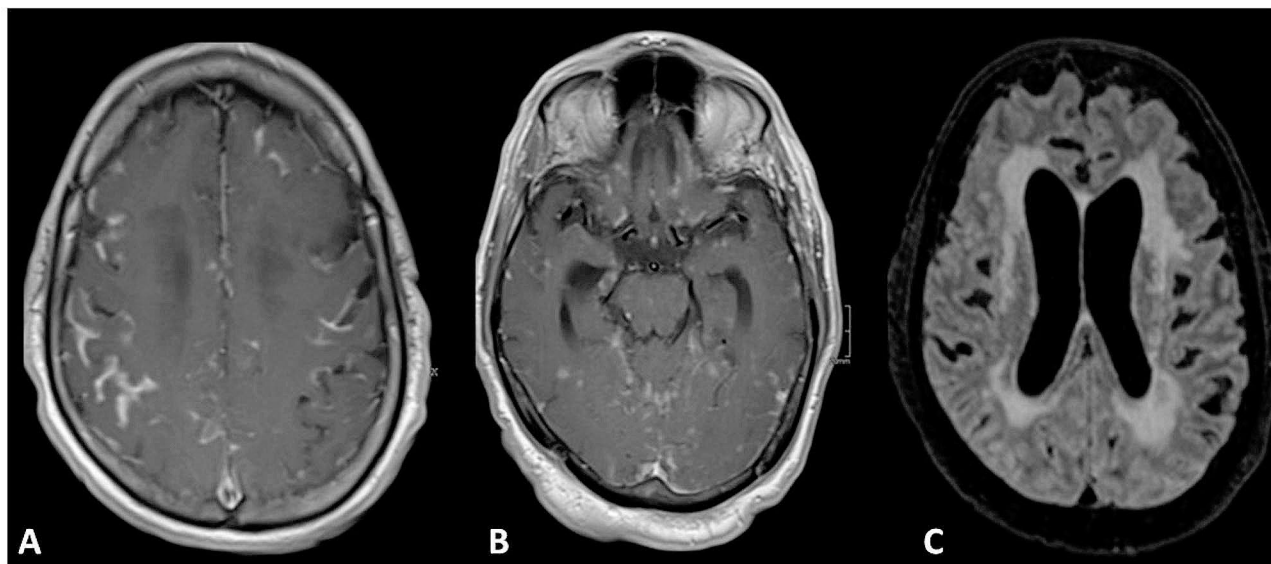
Axial magnetic resonance imaging (MRI) of the described patient. A–B: T1-weighted MRI showing supratentorial and infratentorial leptomeningeal and nodular enhancement. C: Fluid-attenuated inversion recovery (FLAIR) showing deep white matter hyperintensities and increased volume of the ventricular system
